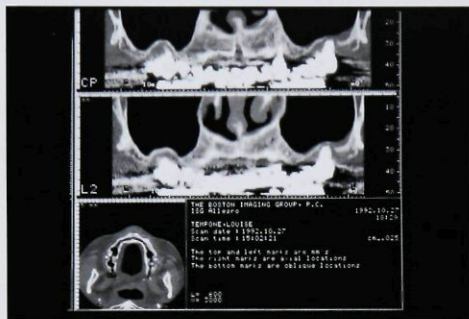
Preoperative CT scan from patient LT. Note large pneumatization of the right sinus.
